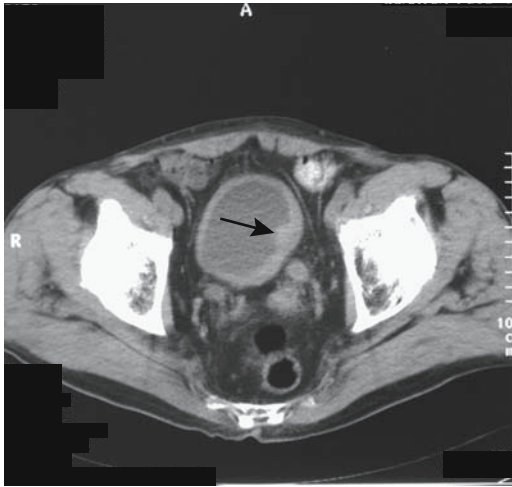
Bladder tuberculosis in a patient with previous renal tuberculosis. Computed tomography shows a thick walled shrunken bladder and a nodule projecting from the wall (arrows). The ureters are dilated. (Courtesy of Egle Jonaitiene, M.D., Kaunas Medical University, Kaunas, Lithuania.)
